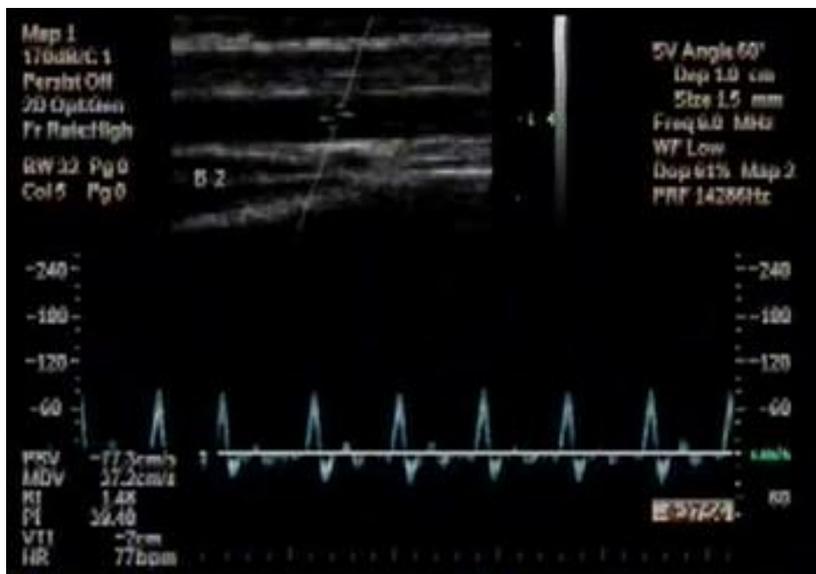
Doppler waveform demonstrating almost absent flow in brachial artery during occlusion by cuff.
